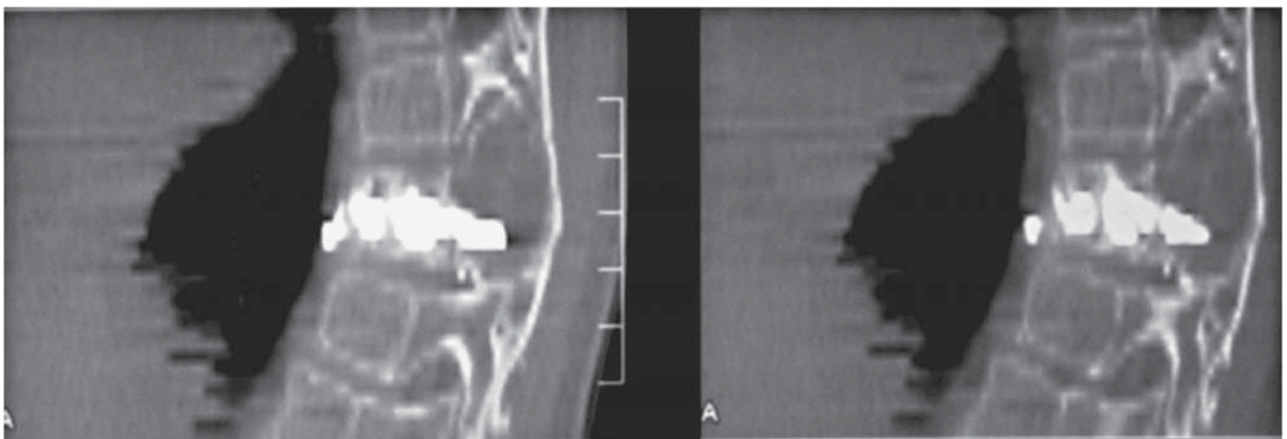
9-year-old female admitted in emergency for acute paraparesis. Partial decompressive laminectomy was performed on admission. The patient improved and an endovascular and percutaneous treatment was suggested. A) Sagittal T2W MRI shows a lytic lesion at T9. B) Axial CT shows a large expansive lytic lesion at T9. C) CT control after direct sclerotherapy of the lytic lesion. D) Sagittal MPR-MDCT reconstruction: final control after percutaneous sclerotherapy.
